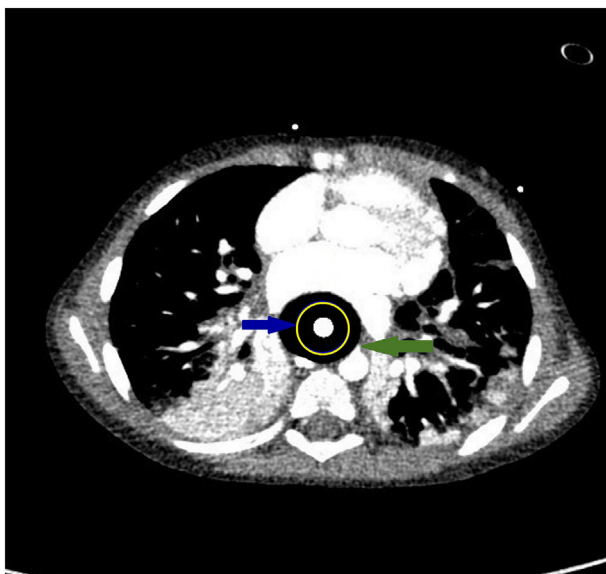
Axial contrast-enhanced CT of the chest showing a linear enhanced structure arising from the anterior mid-thoracic aorta, where the “arrowhead” represents the aorto-esophageal fistula. Note the inflated Sengstaken–Blakemore tube within the mid-esophagus, as indicated by the “arrowed circle”.
